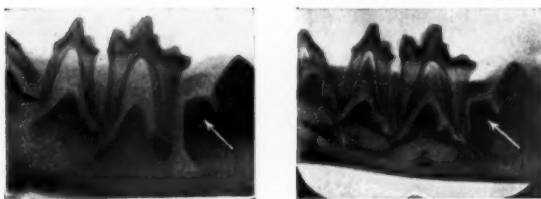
b. Roentgenograms of the mandible bone from Siss, to the left, and Lisken, to the right. The thickness of the calcified enamel-dentin cap on tubercle indicated by the arrow (permanent tooth) is for Siss 2,3 mm and for Lisken 2,5 mm. Notice at the same time the thinner rootwalls of the deciduous teeth of Eva compared with those of Siss and Lisken. — Furthermore it may also be noticed the more crowding of the teeth in the jaw of Eva.
